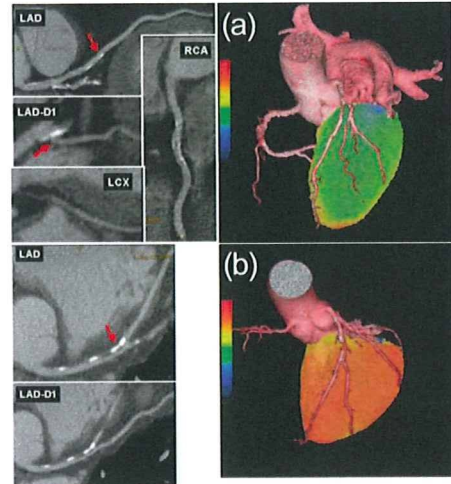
動脈硬化症例における血管反応性の画像評価。CT angiographyによる血管形態画像と¹⁵O-標識水PETによる心筋灌流画像の融合。共に狭窄が認められるが、(a) 血流予備能が低下している例 (b) 血管予備能が保たれている例 (Finland, Truku PETセンター Knuuti 教授提供)
